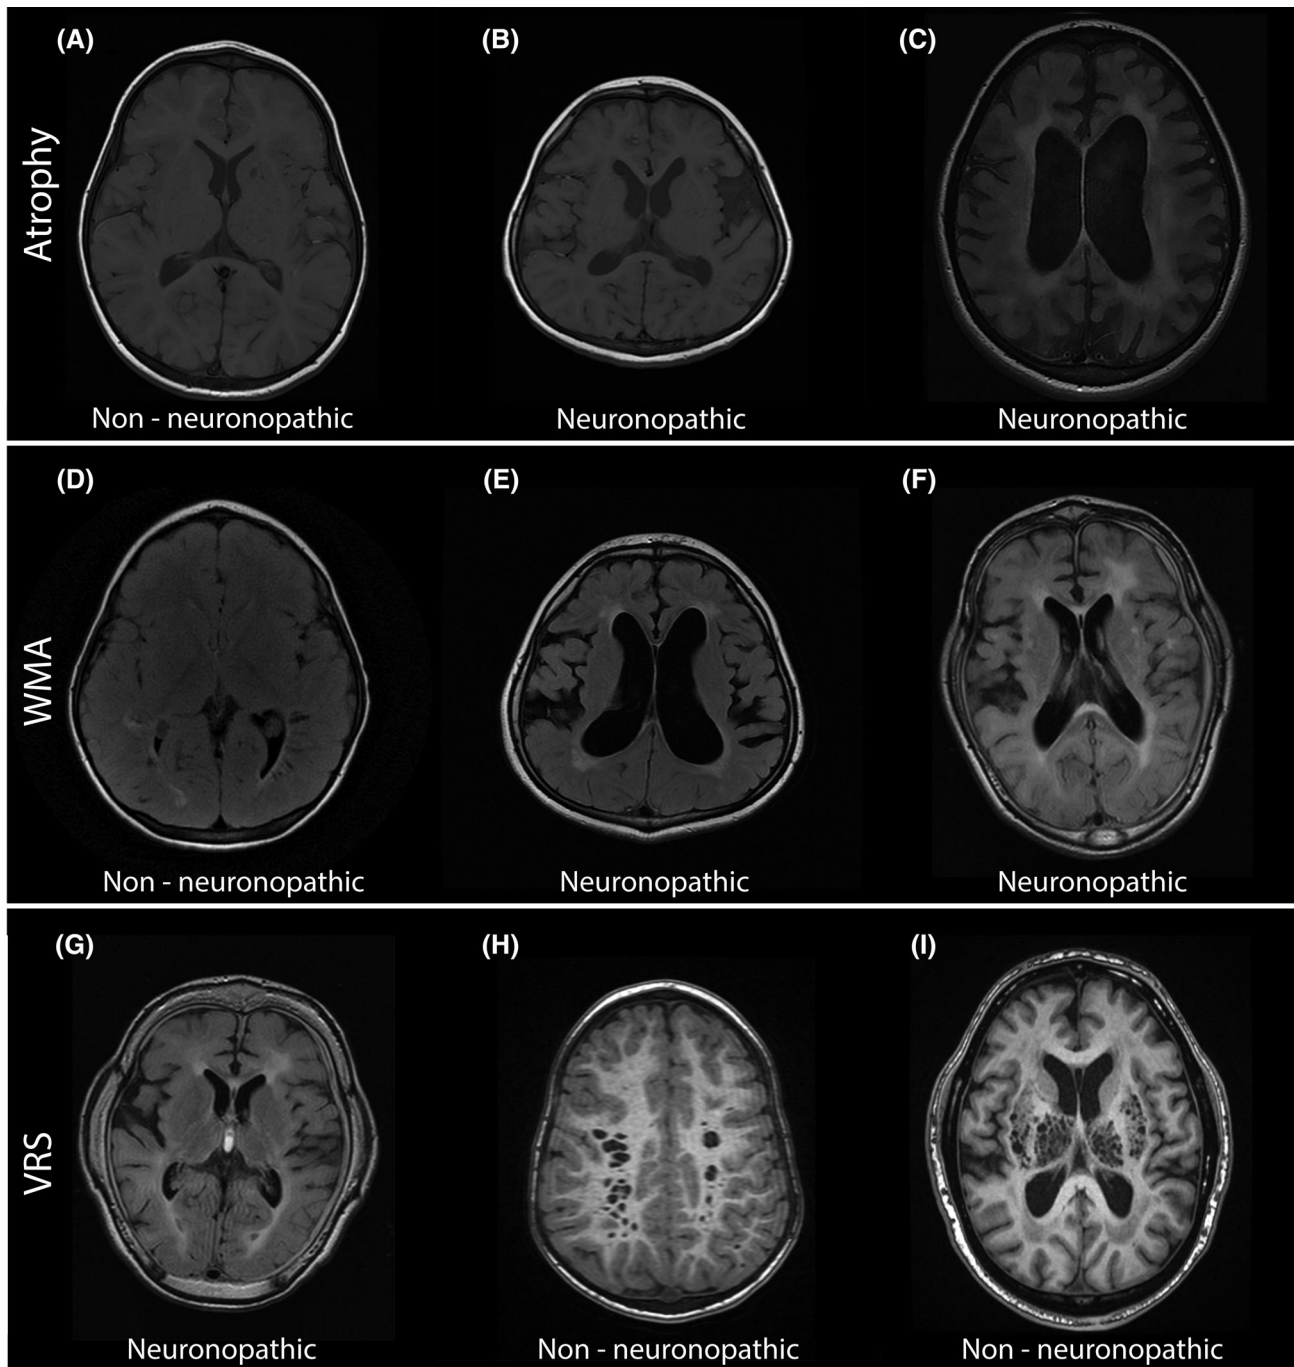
Magnetic resonance images of MPS II patients. Examples of MRI images ordered from mild (left) to severe (right). A-C show atrophy, D-F show white-matter abnormalities (WMA), and G-I show Virchow-Robin spaces (VRS). A, T1 image of a non-neuronopathic patient at 2.3 years; B, T1 image of a neuronopathic patient at 4.2 years; C, T1 image of a neuronopathic patient at 14.2 years; D, T2-FLAIR image of a non-neuronopathic patient at 4.1 years; E, T2-FLAIR image of a neuronopathic patient at 7.2 years; F, T2-FLAIR image of a neuronopathic patient at 8.0 years; G, T2-FLAIR image of a neuronopathic patient at the age of 10.2 years; H, processed image of a non-neuronopathic patient at 4.1 years; I, processed image of a non-neuronopathic patient at 46.9 years
